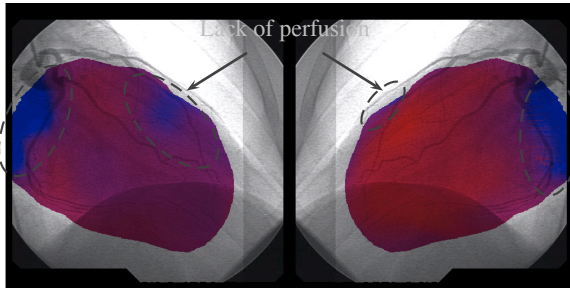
Patient 4 : Right Anterior Oblique (RAO) projection of 30°. Mirror coronarographic views with the associated myocardial perfusion data from tomoscintigraphy. In the SPECT-data, the lack of perfusion appears in blue whereas a normal perfusion is visualized in red.
